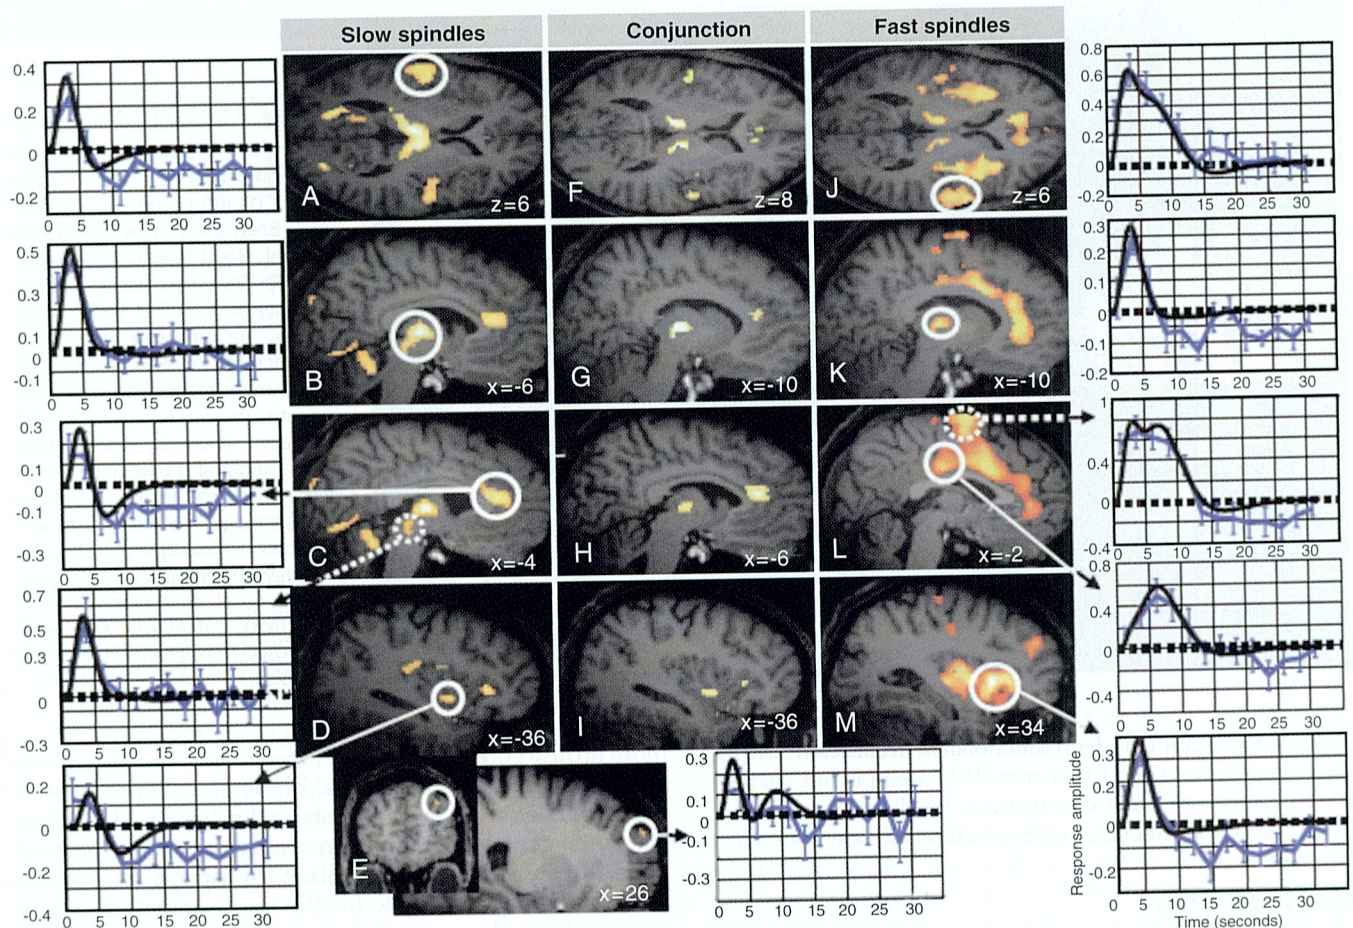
Functional neuroanatomy of sleep spindles (functional magnetic resonance imaging). Brain responses associated with all sleep spindles (i.e., slow and fast; center panels, F to I), slow spindles (left panels, A to E), and fast spindles (right panels, J to M), as compared to the baseline brain activity of non-REM sleep. Activations were significant at $P < .05$, corrected for multiple comparisons. The side panels show the time course (in seconds) of fitted response amplitudes (in arbitrary units) during spindles in the corresponding circled brain area. All responses consisted of regional increases of brain activity. (Modified from Schabus M, Dang-Vu TT, Albouy G, et al. Hemodynamic cerebral correlates of sleep spindles during human non-rapid eye movement sleep. *Proc Natl Acad Sci U S A.* 2007;104:13164-13169. Copyright 2007 National Academy of Sciences, U.S.A.)
